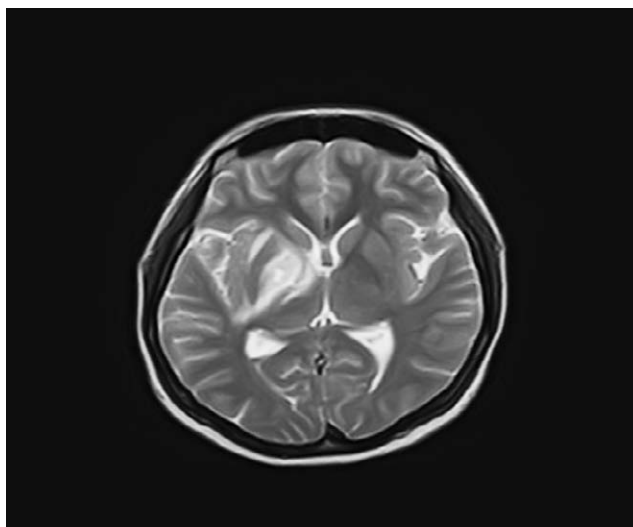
Brain MRI — changes in the area of the basal ganglia and mesencephalon – transverse section
